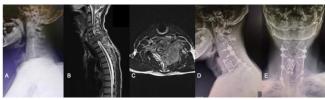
A 51-year-old man was diagnosed with lower cervical tuberculous spondylitis after a 2-month history of neck pain with limbs weakness. Plain radiograph and MRI showed destruction of C6-C7 vertebral bodies with extensive paravertebral and epidural abscesses (A-C), combine anterior and posterior approach was done and final follow-up radiographs showed good fixation and fusion (D-E).
